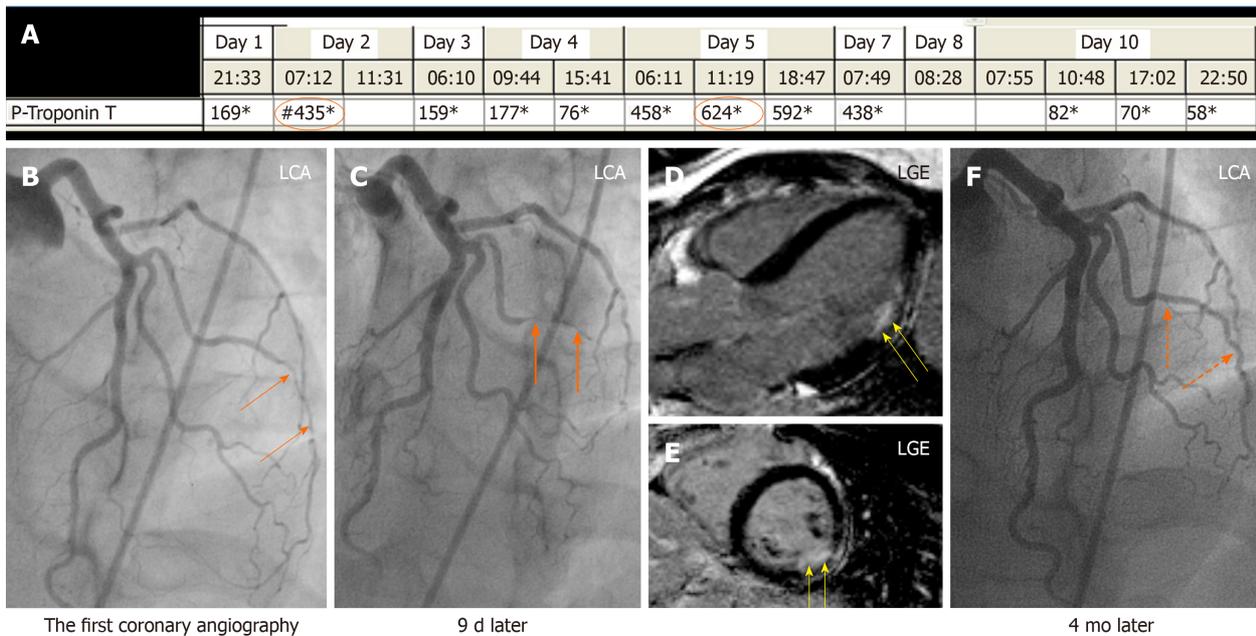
A case of obstructive coronary artery disease due to spontaneous coronary artery dissection. A 35-years-old female patient with a spontaneous coronary artery dissection (SCAD) of the diagonal artery with documented myocardial infarction (MI) by cardiac magnetic resonance imaging and obstructive coronary artery stenosis. A: Recurrent troponin elevation with a rise and/or fall pattern (orange circles); B: A diagonal artery with a peripheral stenosis (thin orange arrows); C: Proximal propagation of diagonal artery narrowing during repeated left coronary artery angiography 9 d later (thick orange arrows); D and E: Cardiac magnetic resonance imaging shows MI corresponding to the diagonal artery supply territory (yellow arrows); F: Follow up left coronary artery angiography 4 mo later reveals complete resolution of the diagonal artery lesion consistent with SCAD (broken orange arrows). Consequently, this patient has documented MI caused by obstructive coronary artery disease due to SCAD. LGE: Late gadolinium enhancement; LGA: Left coronary artery.
